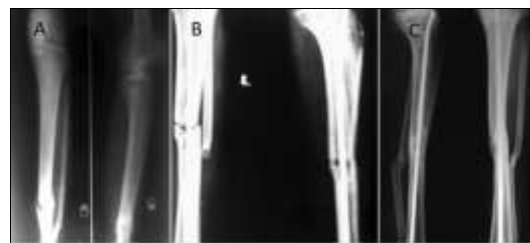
Radiographs of a tibial nonunion before surgery, after surgery, and after 28 weeks: (A) Pre-operative radiograph of a patient with an infected nonunion, (B) post-operative radiograph after surgery, and (C) radiograph showing bone union at 28 weeks
